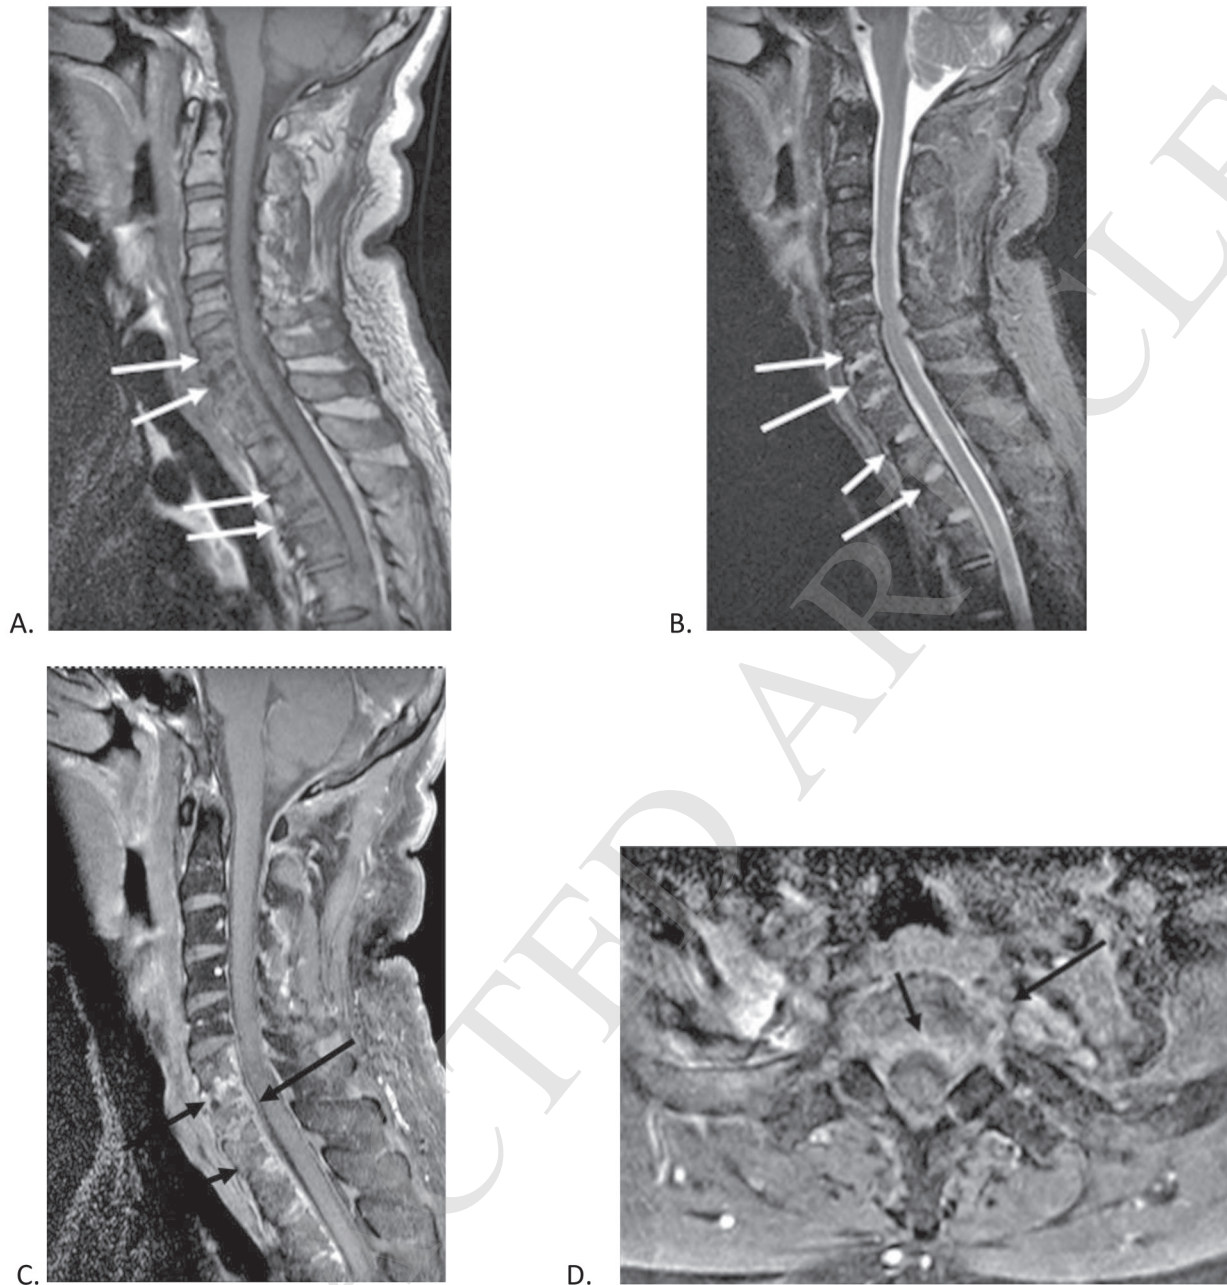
Aspergillus spondylitis*. A 60-year-old male, with diabetes presented with neck pain and weakness of the upper extremities of one month duration. A.T1- weighted sagittal MRI and B.T2-weighted, fat-saturated sagittal MRI show diffuse T1 hypointensity/T2 hyperintensity extending from C6 to the T4 vertebral bodies. There are endplate irregularities with subchondral low signal intensity (white arrows) adjacent to the discs and some hypointense foci in the anterior aspect of discs (white arrows). Abnormal T2 hyperintensity in the C6-7 down to T3-4 disc spaces is also seen. C. Postgadolinium, fat-saturated T1-weighted sagittal MRI reveals diffuse bone marrow enhancement (black arrows) at the C6 to T4 vertebrae corresponding to the abnormal vertebral bone marrow signal. Evidence of disc enhancement and thin enhancing ventral epidural soft tissue and anterior paraspinal enhancement (black arrows) is seen. D.Postgadolinium, fat-saturated T1-weighted axial MRI confirms the vertebral marrow enhancement, enhancing ventral epidural, and thin anterior paraspinal soft tissue. His blood culture was positive for *Aspergillus fumigatus*. He was treated for fungal spondylitis with antifungal therapy.
